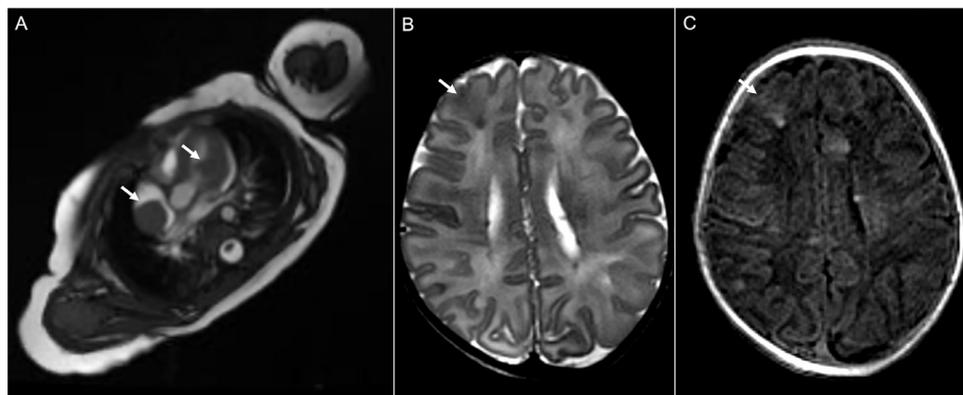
A 20-day-old male patient. Cardiac MRI balanced steady-state free precession in 4-chamber view (A) shows 2 cardiac rhabdomyomas: one in right atrium and one in left ventricle (white arrows). Brain MRI axial images (B, C) show a cortical-subcortical tuber (white arrow) in right frontal lobe that appear hypointense on T2w sequence (B) and hyperintense on T1w sequence (C).
